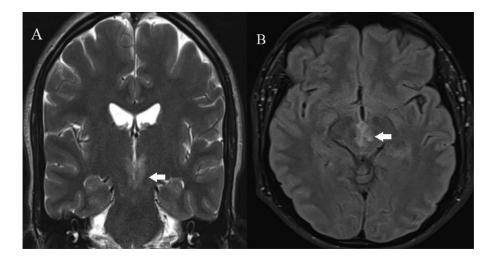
Cerebral MRI on coronal T2 (A) and axial FLAIR (B) sequences showed hyperintensity on the rostral midbrain (arrows).
